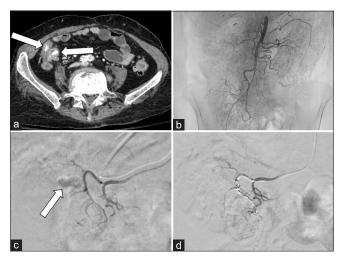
Case example of active lower gastrointestinal bleed. (a) A single slice axial image from a multiphase computed tomography angiography (CTA) demonstrating active bleeding in the proximal ascending colon (white arrows). (b) Selective superior mesenteric artery arteriogram demonstrates patent vasculature without arterial bleeding. (c) Superselective angiogram demonstrates the focus of active bleeding (white arrow) corresponding to the location on prior CTA. (d) Repeat superselective angiogram demonstrating successful coil embolization of the target vessel with cessation of bleeding.
